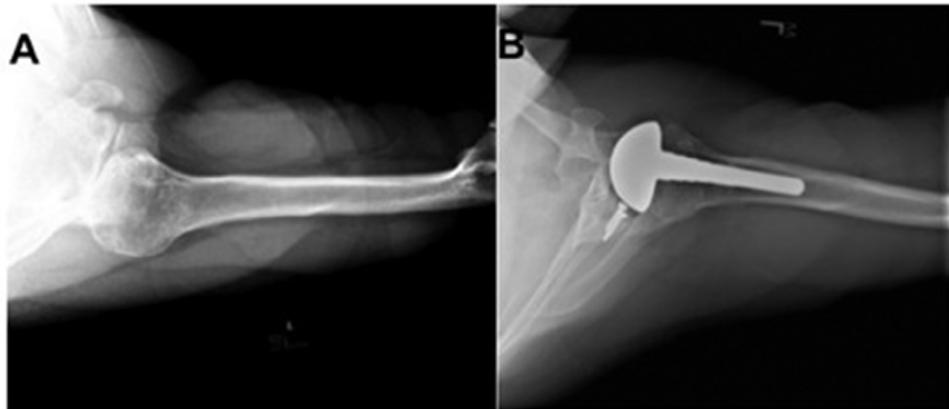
Preoperative (A) and postoperative (B) axillary radiographs show correction of glenoid retroversion and posterior humeral subluxation with a healed and incorporated graft after posterior glenoid bone grafting.
